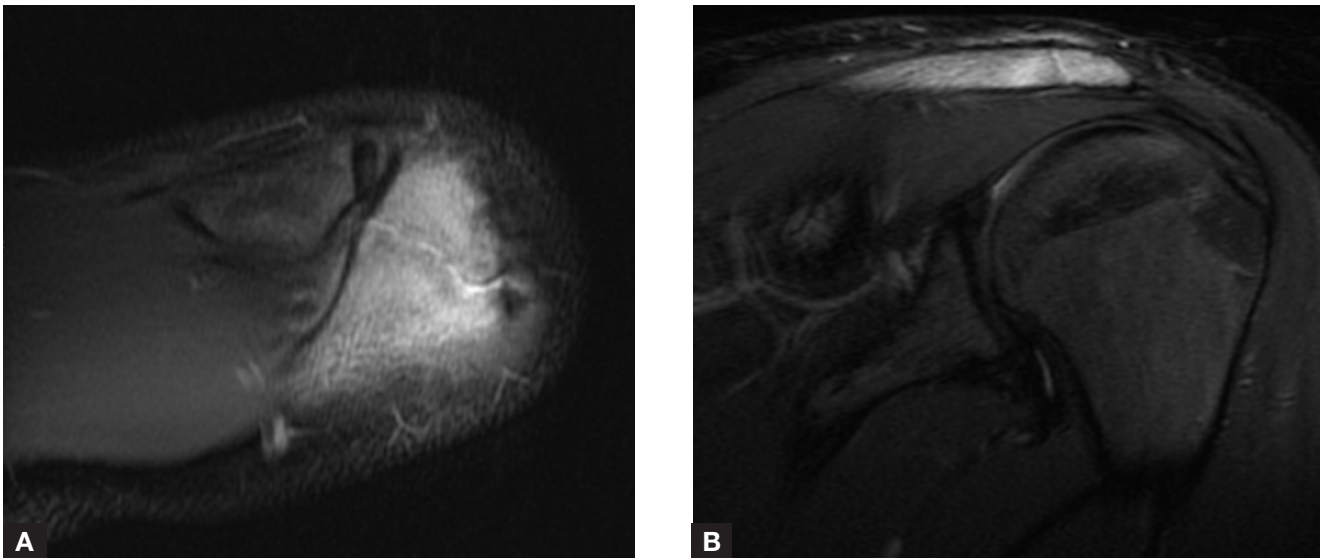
Fat-suppressed T_2 -weighted magnetic resonance imaging shows intense bone-marrow edema involving acromion and os acromiale. (A) axial (repetition time, 4500 ms; echo time, 70 ms) and (B) coronal (repetition time, 5000 ms; echo time, 72 ms) views.
